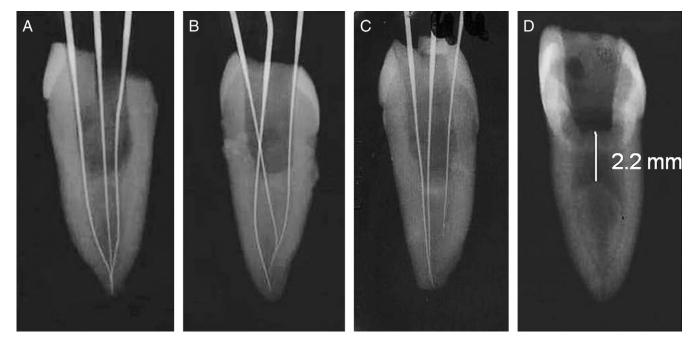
(*A-C*) Radiographs of mandibular molars exposed from the mesial direction (the distal roots were resected) showing the pathway of the accessory mesial canals. Files were inserted into the MB, ML, and accessory canals. (*D*) The depth of dentin removal while troughing to negotiate the accessory canal using the pulp chamber floor as a reference.
